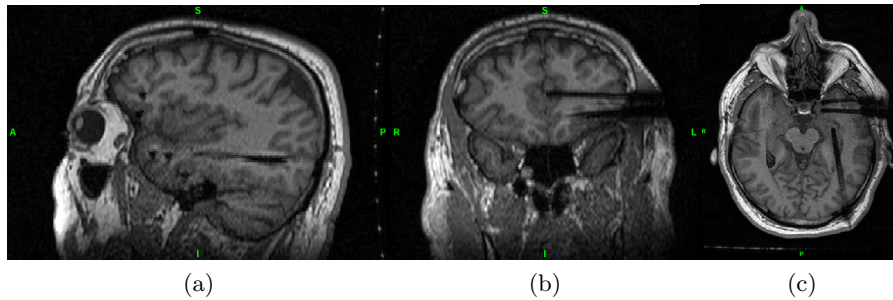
MRI scan of a subject with SEEG electrodes implanted. Sagittal (a), coronal (b) and transverse (c) sections.
